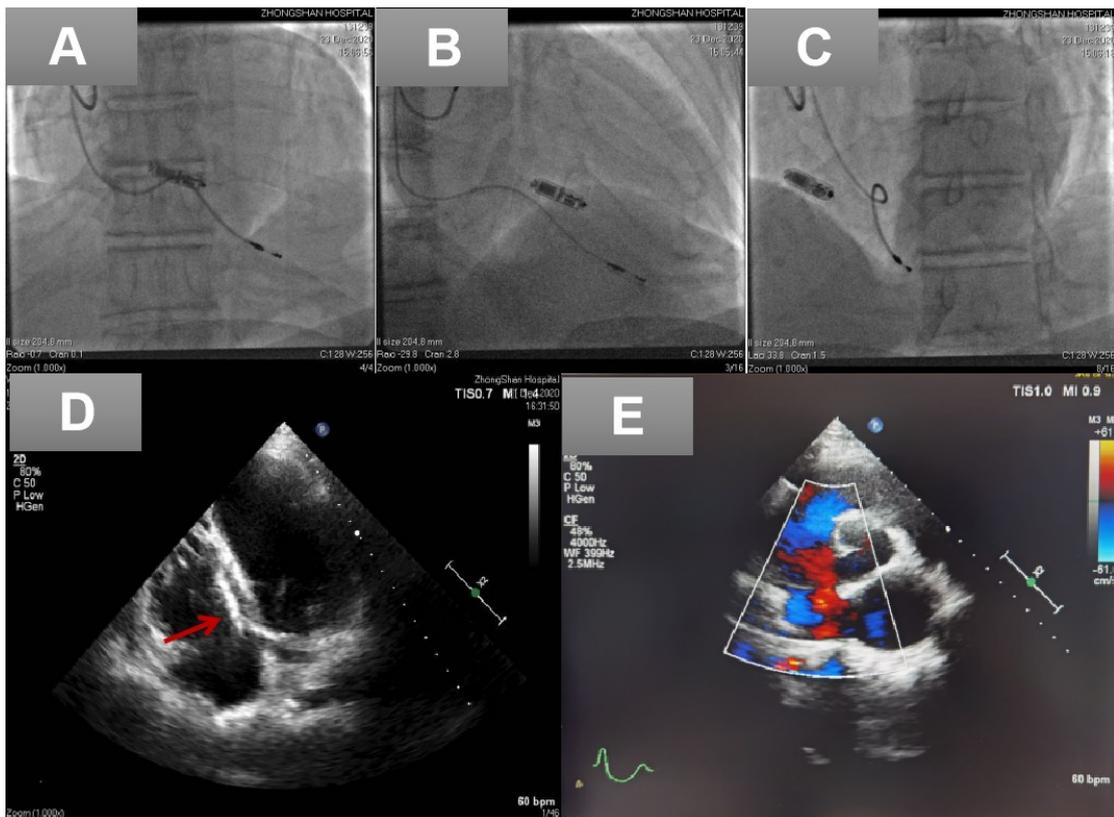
The images of the new Micra TPS after re-implantation: The fluoroscopic images at poster-anterior position (A), at RAO 30° (B) and at LAO 35°(C); The echocardiogram showed (D) the location of Micra TPS (red arrow) at the low septum of the right ventricle; (E) no valve damage or worsening of [tricuspid regurgitation](#) after retrieval and re-implantation.
